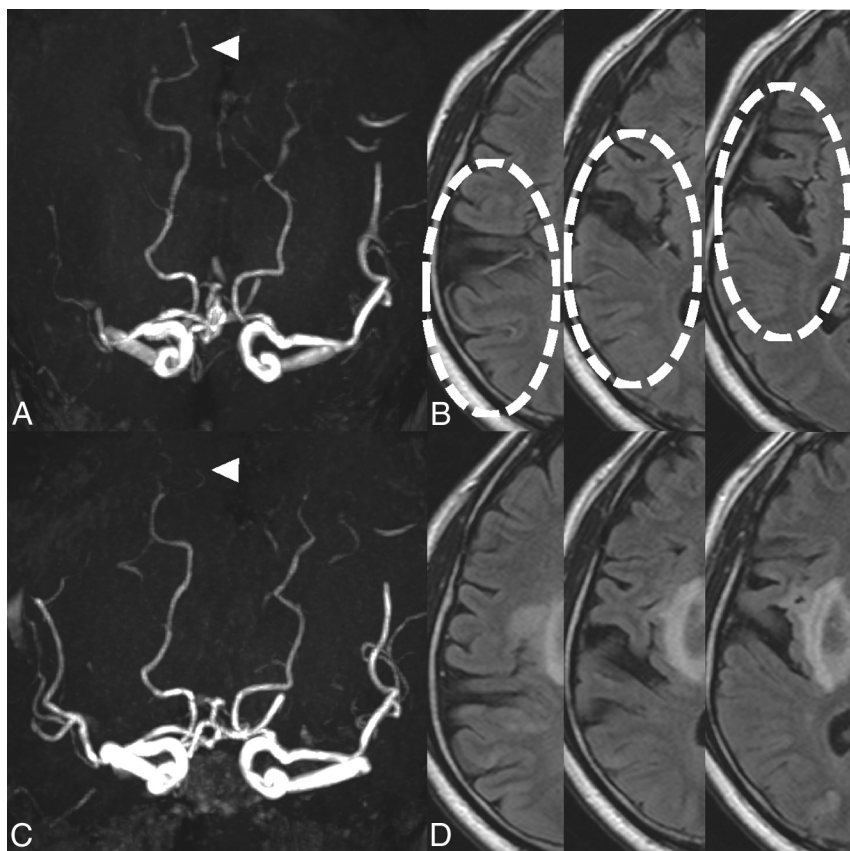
Reversion of collateral signs on MR images. MRA (A and C) and FLAIR MR imaging (B and D) of a representative patient who experienced early neurologic improvement after IV rtPA. PCA laterality (arrowheads) and hyperintense vessels (dotted circles) were observed before treatment (A and B) but disappeared after thrombolysis (C and D), indicating the reversion of collaterals.
